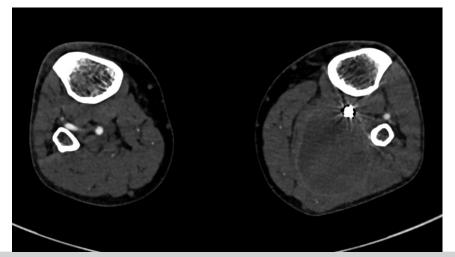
Postoperative computed tomography image showing complete thrombosis and shrinkage of the pseudoaneurysm.
